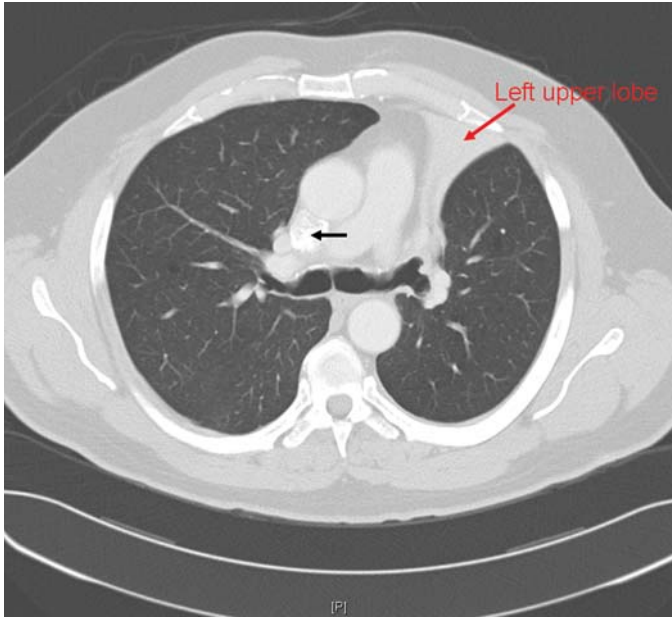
FIGURE e24-3 CT scan demonstrating left upper lobe collapse. The patient was found to have an endobronchial lesion (not visible on the CT scan) resulting in this finding. The superior vena cava (*black arrow*) is partially opacified by intravenous contrast.
